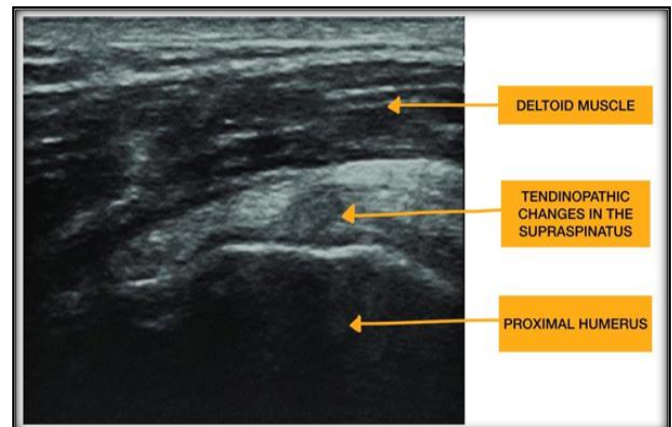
A 54 year old male with right shoulder pain, diagnosed to have supraspinatus tendinosis. Image - Grayscale ultrasound short axis view showing heterogenous echotexture of the supraspinatus tendon.
